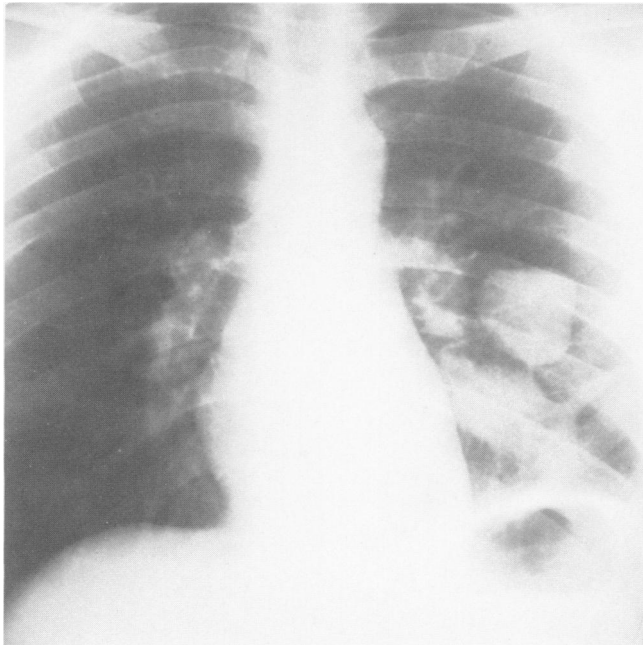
Chest roentgenogram showing some resolution of the previously noted posterior radiodensity but persistence of the radiodensity in the lingular area.
